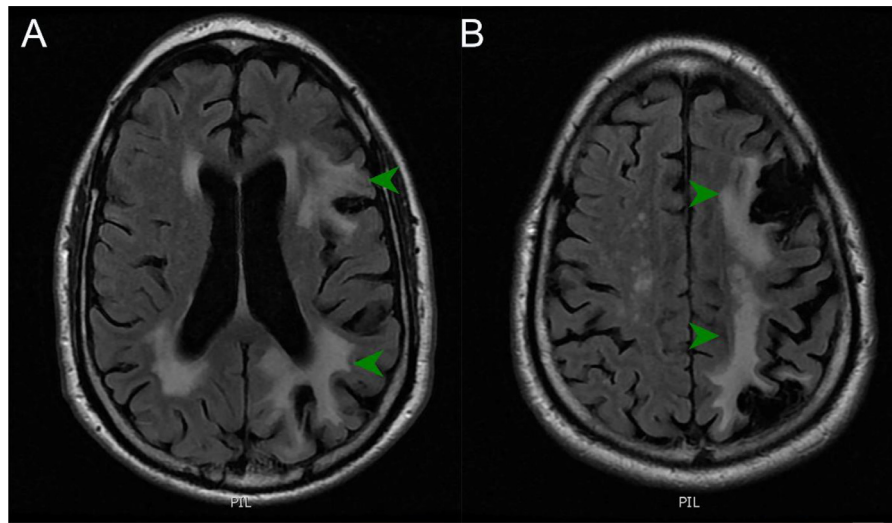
Cerebral white matter hyperintensities and stroke. A, Axial FLAIR at the level of the lateral ventricles demonstrating severe confluent white matter abnormalities involving the left frontal lobe and parietal lobe. B, Axial FLAIR above the ventricles again shows severe confluent white matter abnormalities as well as left parietal and left frontal encephalomalacia from prior ischemic infarctions. Courtesy: Dr. Daniel S. Chow, assistant professor-in-residence, Dr. David Floriolli, program director of diagnostic radiology and Associate Clinical Professor, department of radiological sciences at the University of California Irvine.
